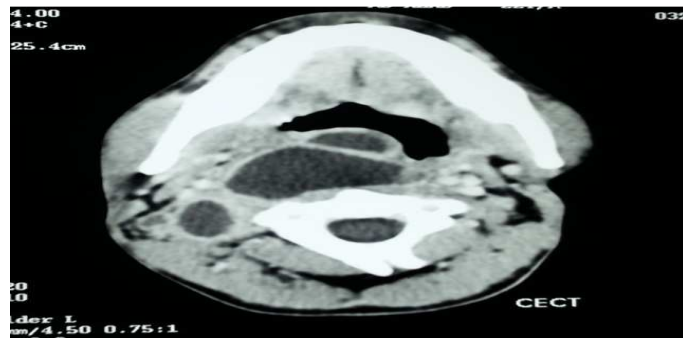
CT scan neck showing trilobulated right retropharyngeal cystic SOL, extending to right perivertebral space
